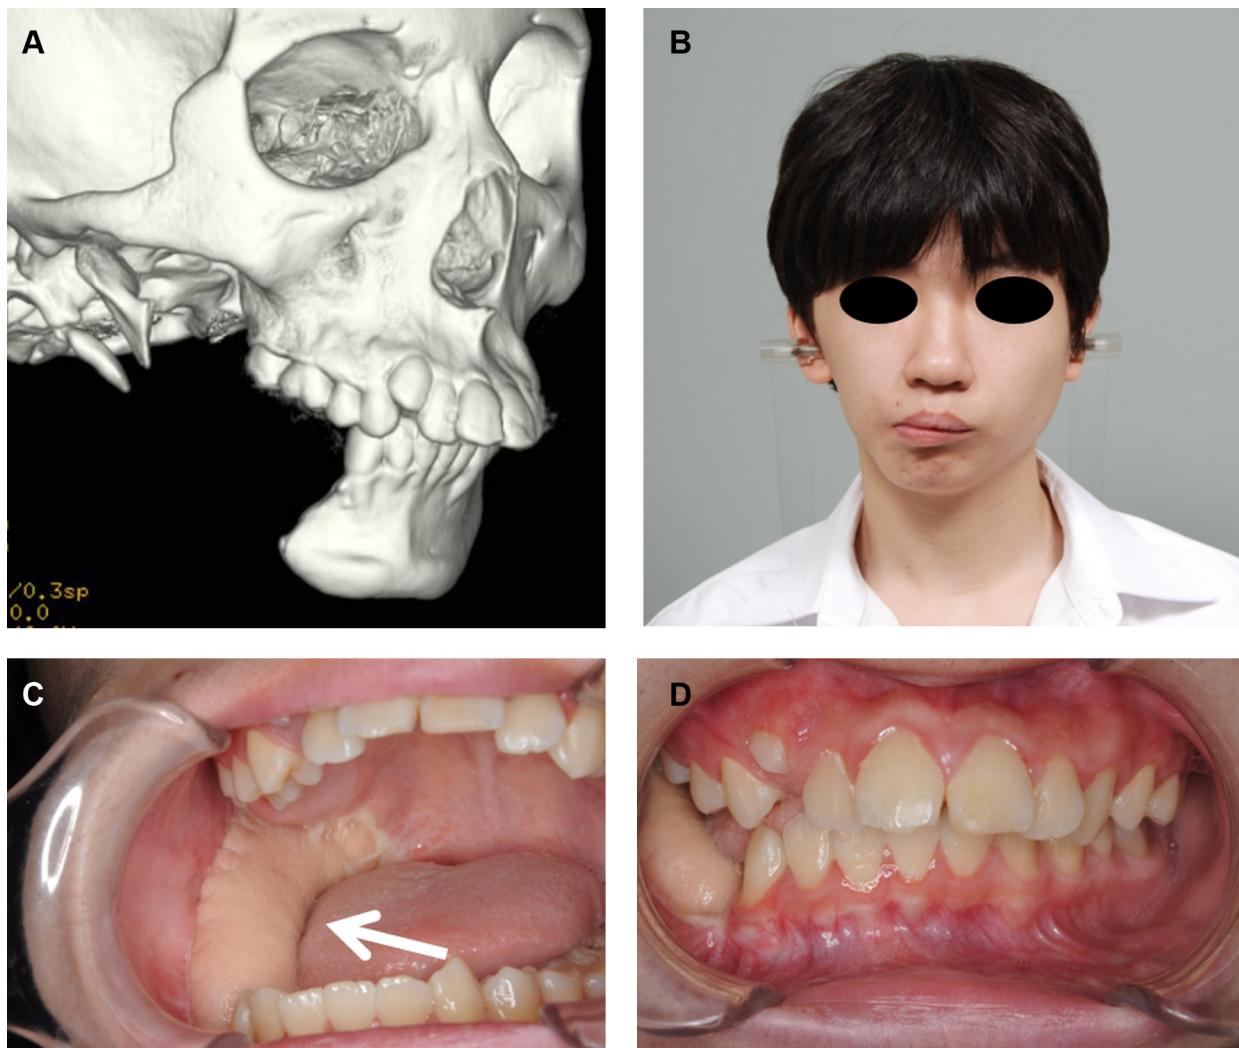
CT image, facial and oral photographs at 7 years and 8 months after surgery. (A) Signs of local recurrence and obvious deformity of the mandible are not seen on the three-dimensional (3D)-CT image. (B) No distinct deformity of the face is found. (C) The reconstructed region in the mandible using a rectus abdominis musculocutaneous flap (arrow). (D) The occlusion has been kept stable.
